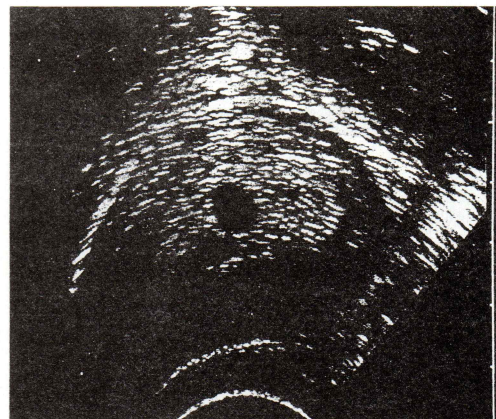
Transvaginal sonography clearly demonstrates a hypoechoic gestational sac surrounded by an achogenic trophoblastic ring at five menstrual weeks.
